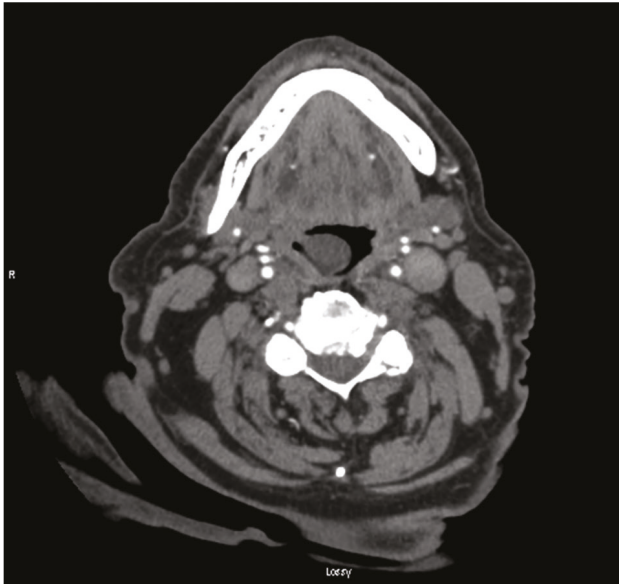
Contrast-enhanced computed tomography axial image demonstrating a pedunculated soft tissue mass projecting from the right oropharynx measuring 2.0 x 1.5 cm.
